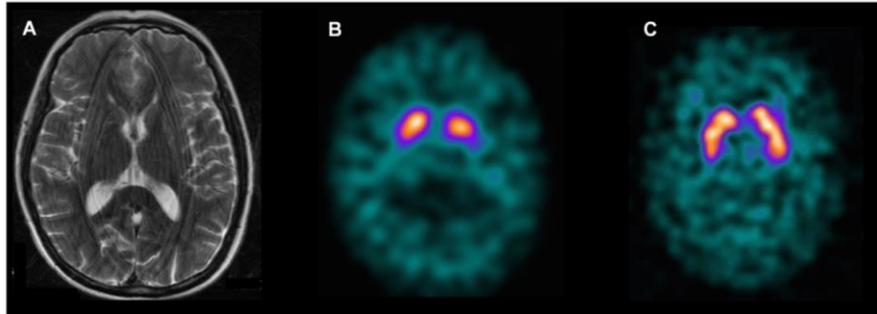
Brain MRI and single photon emission computed tomography (SPECT) dopamine reuptake transporter (DAT)-scan images in case 3. (A) Albeit markedly degraded by movement artefacts, axial MR images showed bilateral T2 hyperintensity within the posterolateral putamina. (B) Dopaminergic striatal innervation was evaluated as DAT density by means of ¹²³I-FP-CIT SPECT. The scan shows marked bilateral reduction of tracer uptake in the striatum, consistent with bilateral nigrostriatal dopaminergic denervation. (C) Normal DAT-scan from an age- and sex-matched subject.
